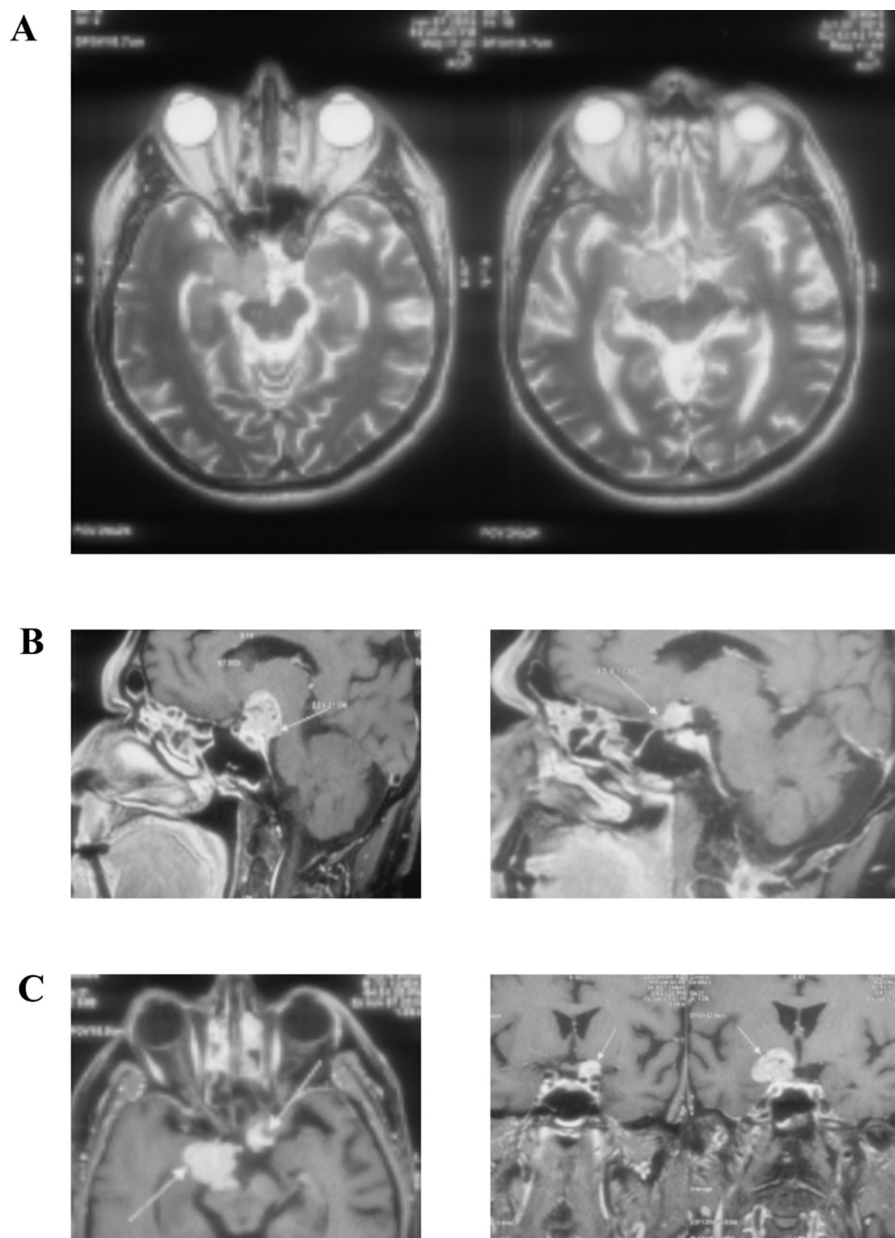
Magnetic resonance imaging (MRI) brain plain and contrast showed a right sellar/suprasellar lesion, T1 hypointense and T2 hyperintense (A) near the dorsum sella extending to the medial temporal region, and cerebral peduncle of size $2.2 \times 1.2 \times 1.1$ cm with homogenous contrast enhancement (B) with no radiological evidence of intra-axial involvement (C).
